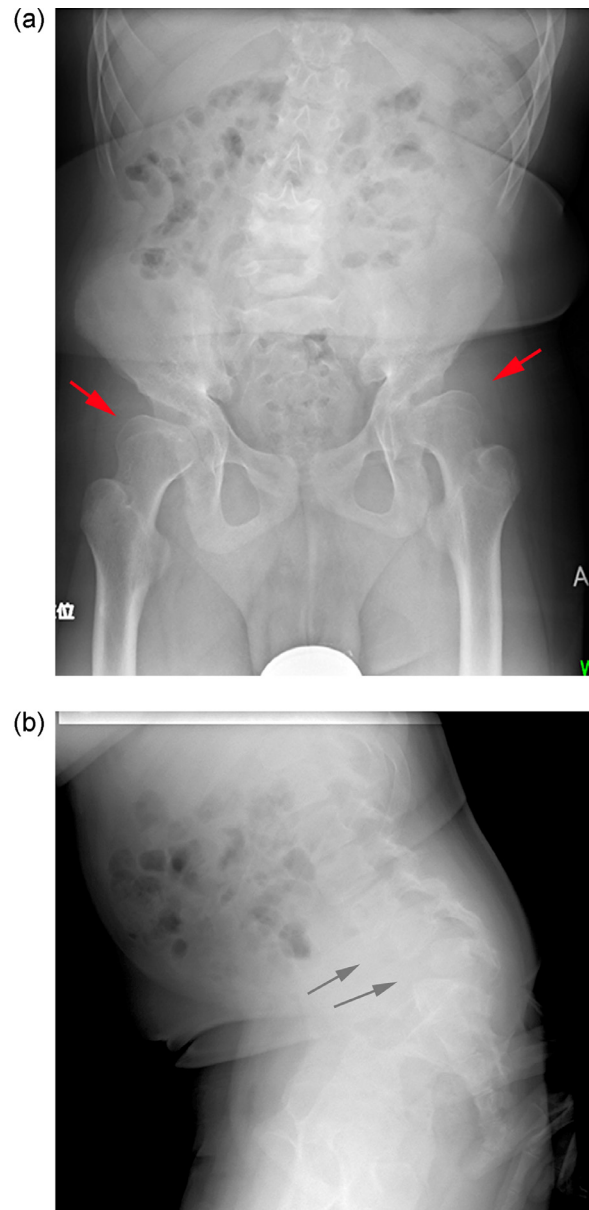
(A) An anterior-posterior pelvic radiograph at 16 years of age showing scoliosis, coxa valga, acetabular dysplasia with deformity of femoral head (arrows), and widened iliac wings. (B) A lateral lumbar radiograph at 16 years of age showing dislocation of the lower lumbar and a fan-shaped deformity (arrows).
